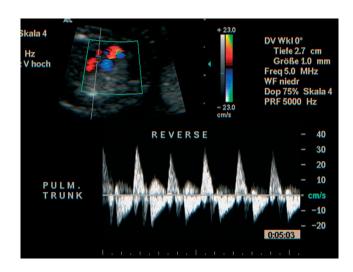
Doppler examination of the pulmonary valve in a fetus with trisomy 13, tetralogy of Fallot with absent pulmonary valve syndrome and patent ductus arteriosus at 12+3 weeks' gestation (Case 4). To-and-fro blood flow is demonstrated during systole and diastole, respectively. PULM, pulmonary.
